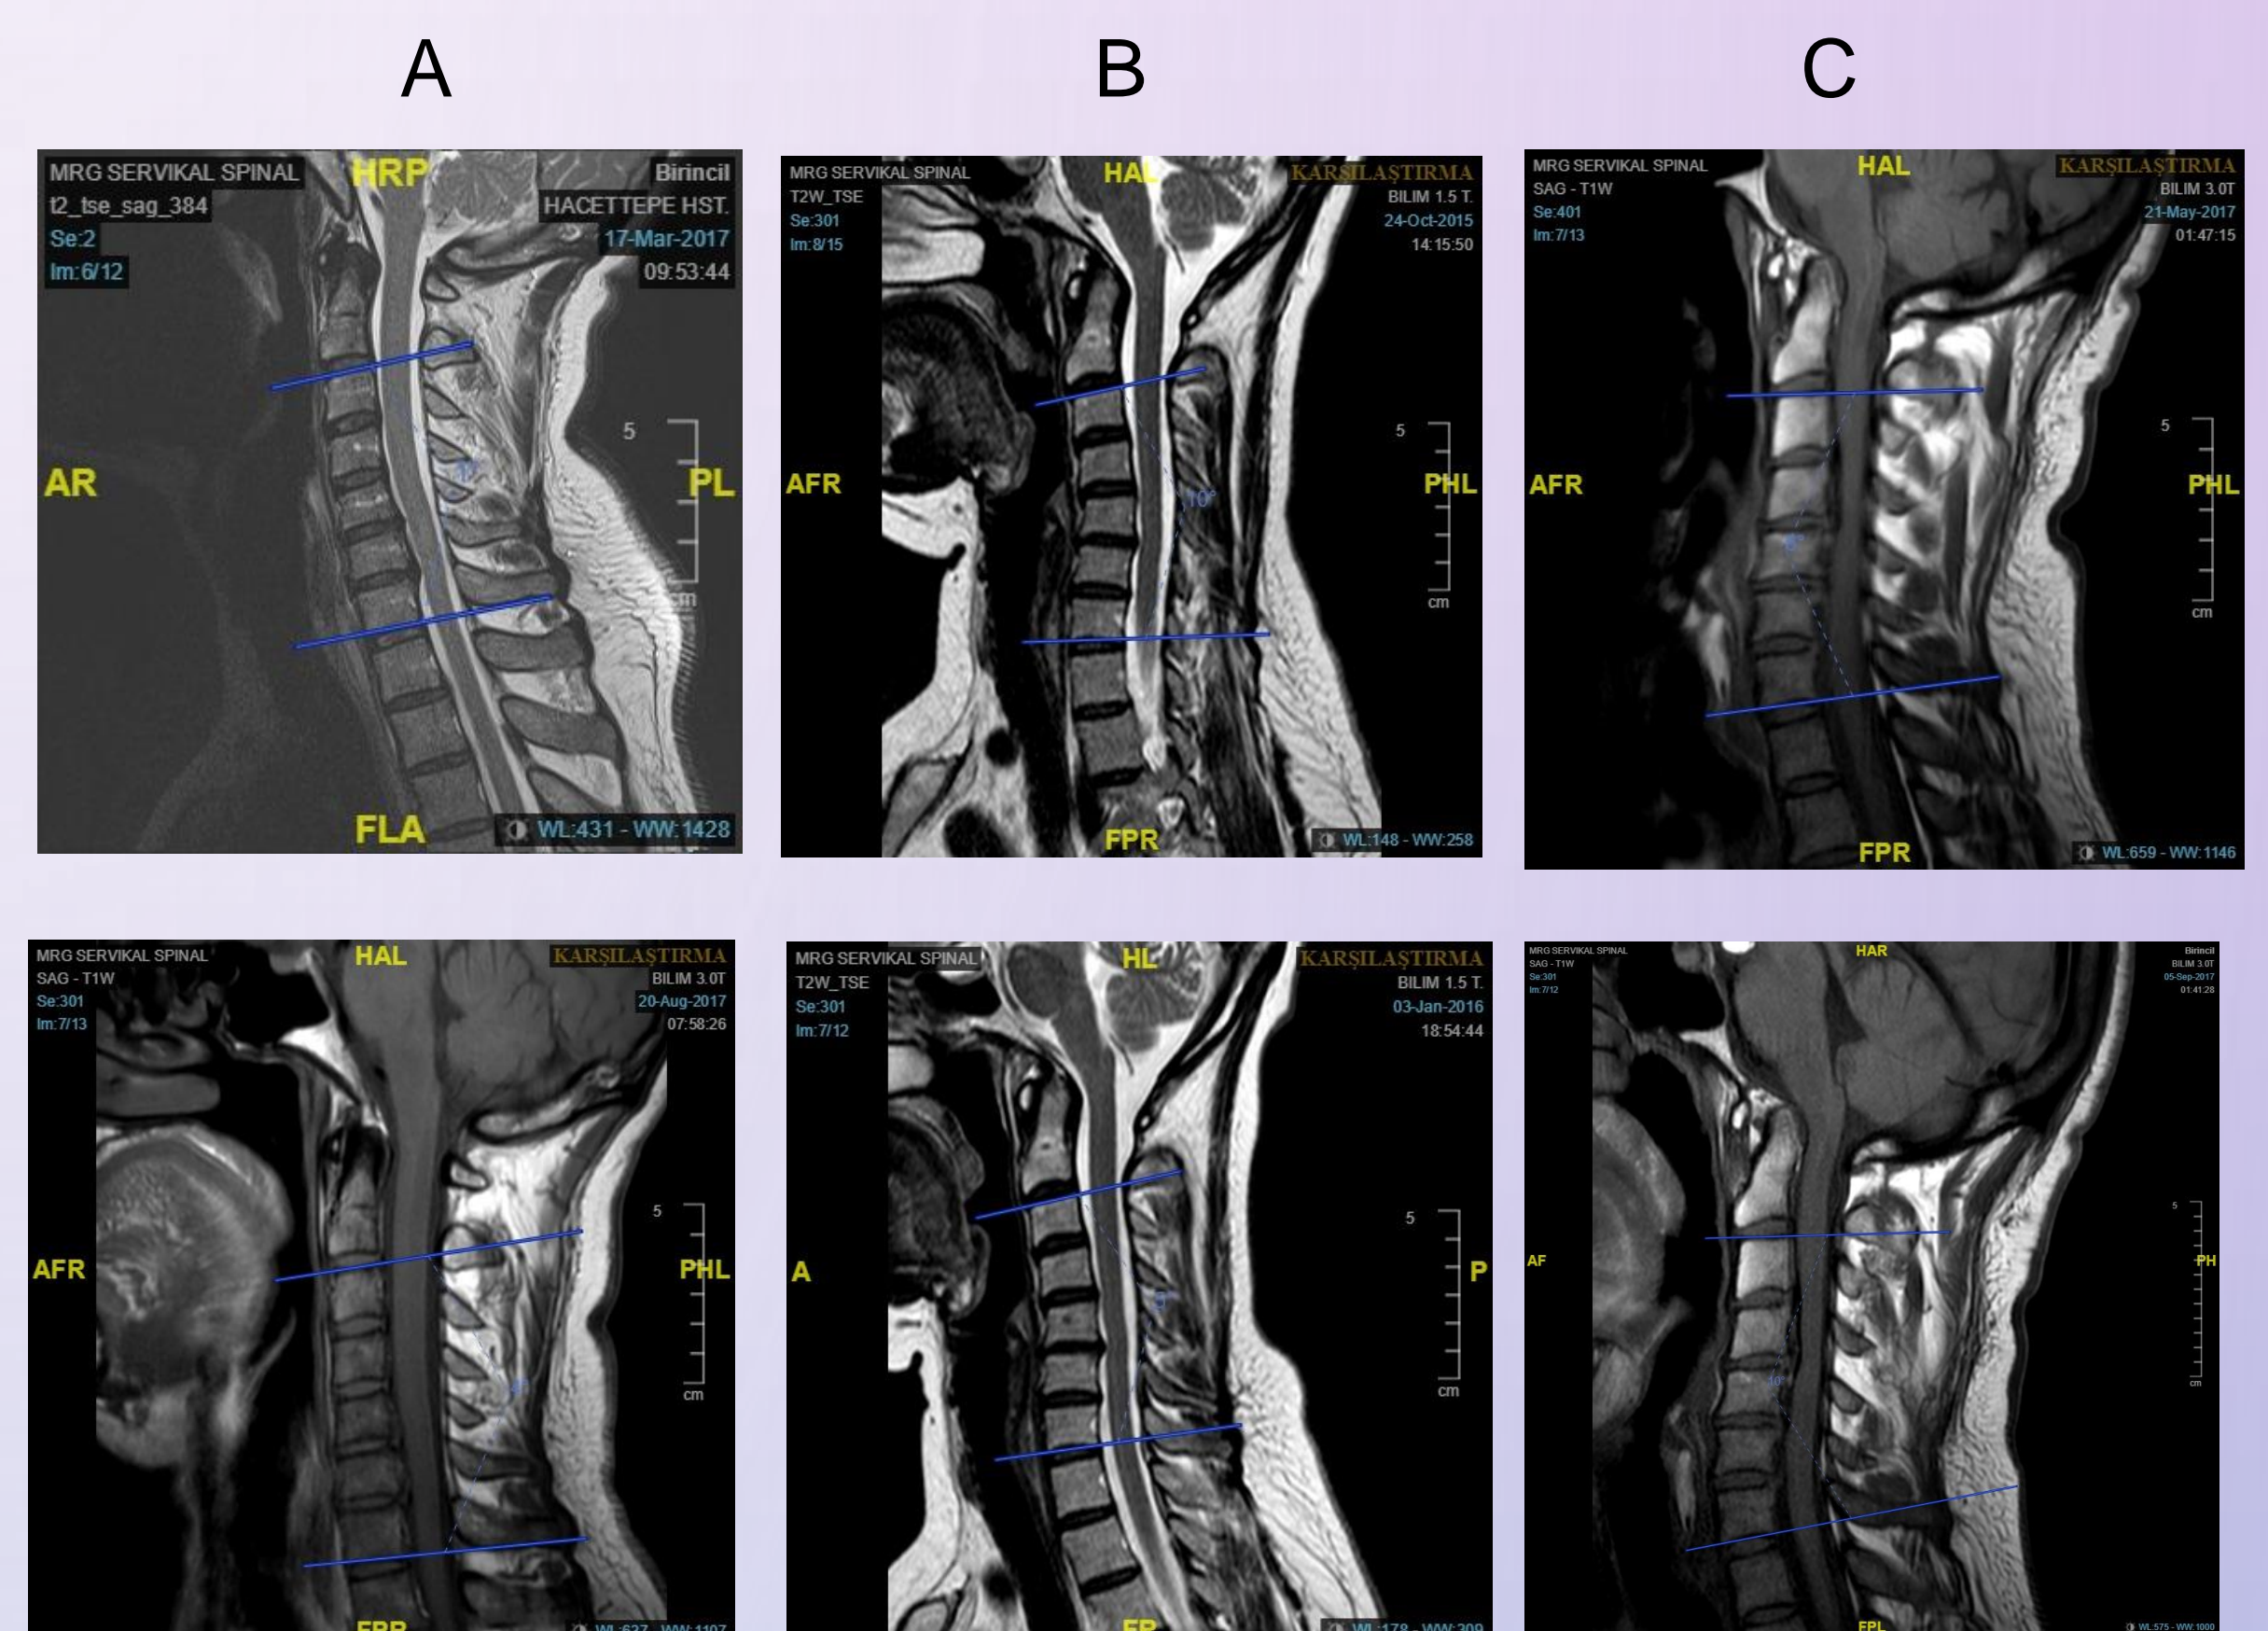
Measurement of cervical lordosis angle using Cobb method in patients with MRI images. A. The findings of the first case before and after treatment B. The findings of the second case before and after treatment C. The findings of the third case before and after treatment .
